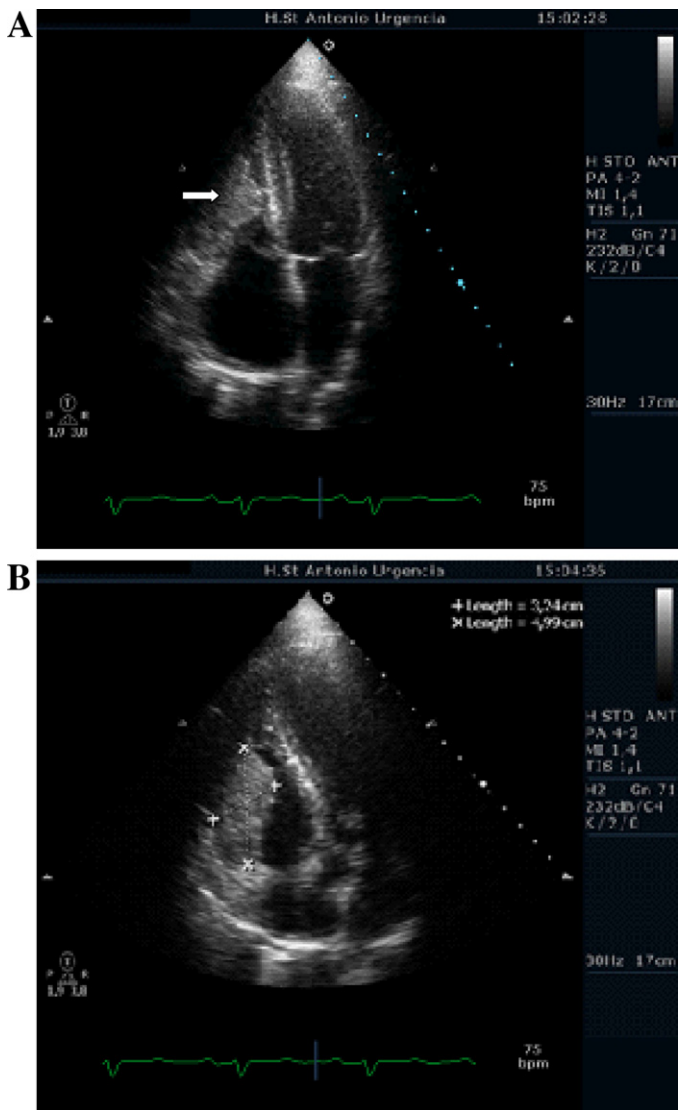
Transthoracic echocardiography apical views (A and B) of the mass (white arrow) mass infiltrating the right ventricle free wall.
